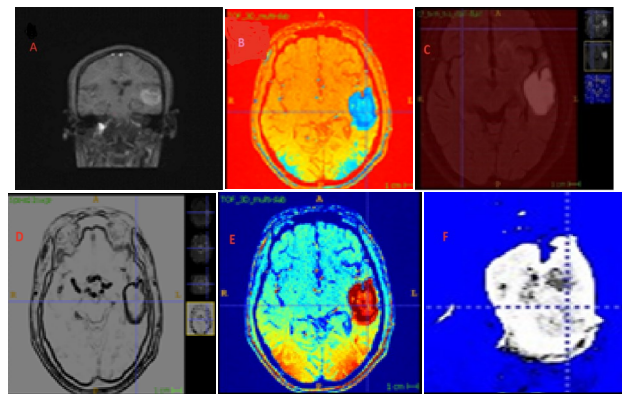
This figure shows the enhanced MRI images of brain tumors. (a) Original MRI image, (b) contrast-enhanced MRI, (c) skull-exposed MRI, (d) edge extraction, (e) decomposed image, (f) clear tumor boundaries. The process highlights the tumor area, enhancing visibility and accuracy for segmentation and diagnosis.
